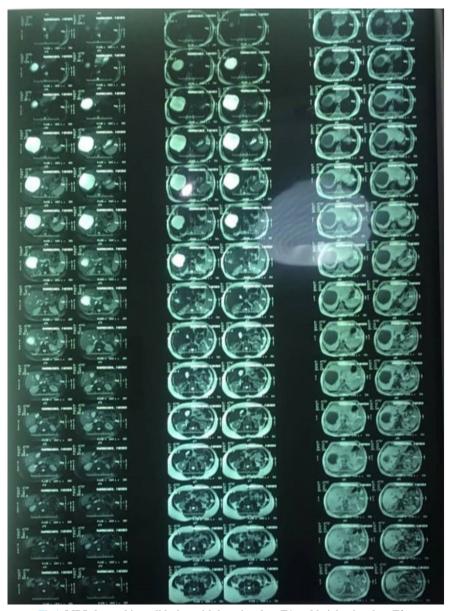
MRI shows thin wall lesion with low signal on T1 and bright signal on T2
